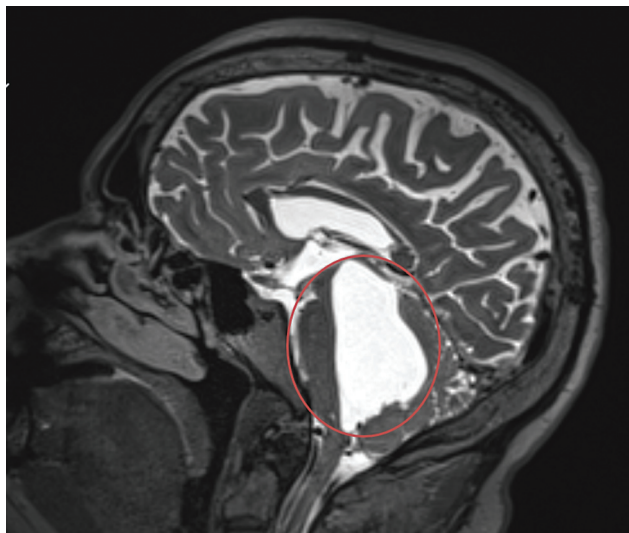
Sagittal T2 magnetic resonance imaging (MRI) image performed before the second shunt (4th ventricle) was inserted.
